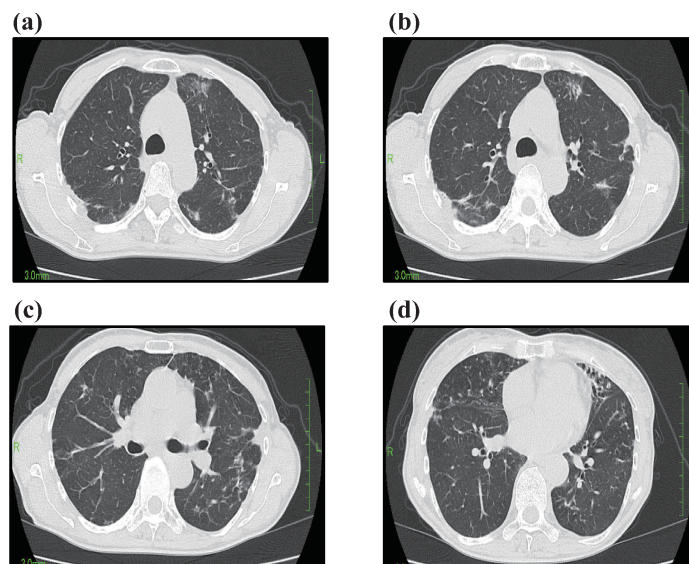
Computed tomography of the chest 1 year after environmental intervention in the patient in Case 1. Upper lobes (a, b); lower lobes (c, d). Ground glass opacities and nodules are present in the right and left upper lobes (a, b). The thin-walled cavity shadow seen on the CT scan the previous year has disappeared (c), and the consolidation has shrunk to be barely visible. Bronchodilation is evident in the middle lobe and lingular segment, but there is only a small amount of sputum in the bronchi (d).
